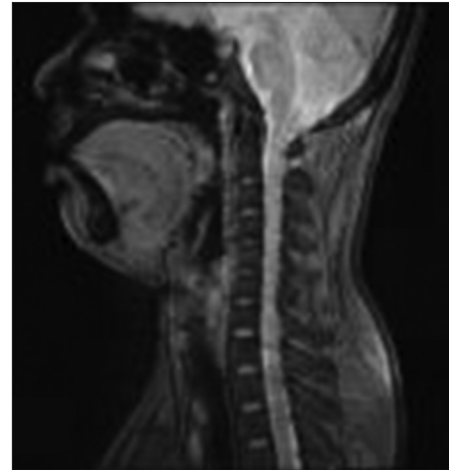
Magnetic resonance imaging of neck showing decrease of hematoma on day 3
